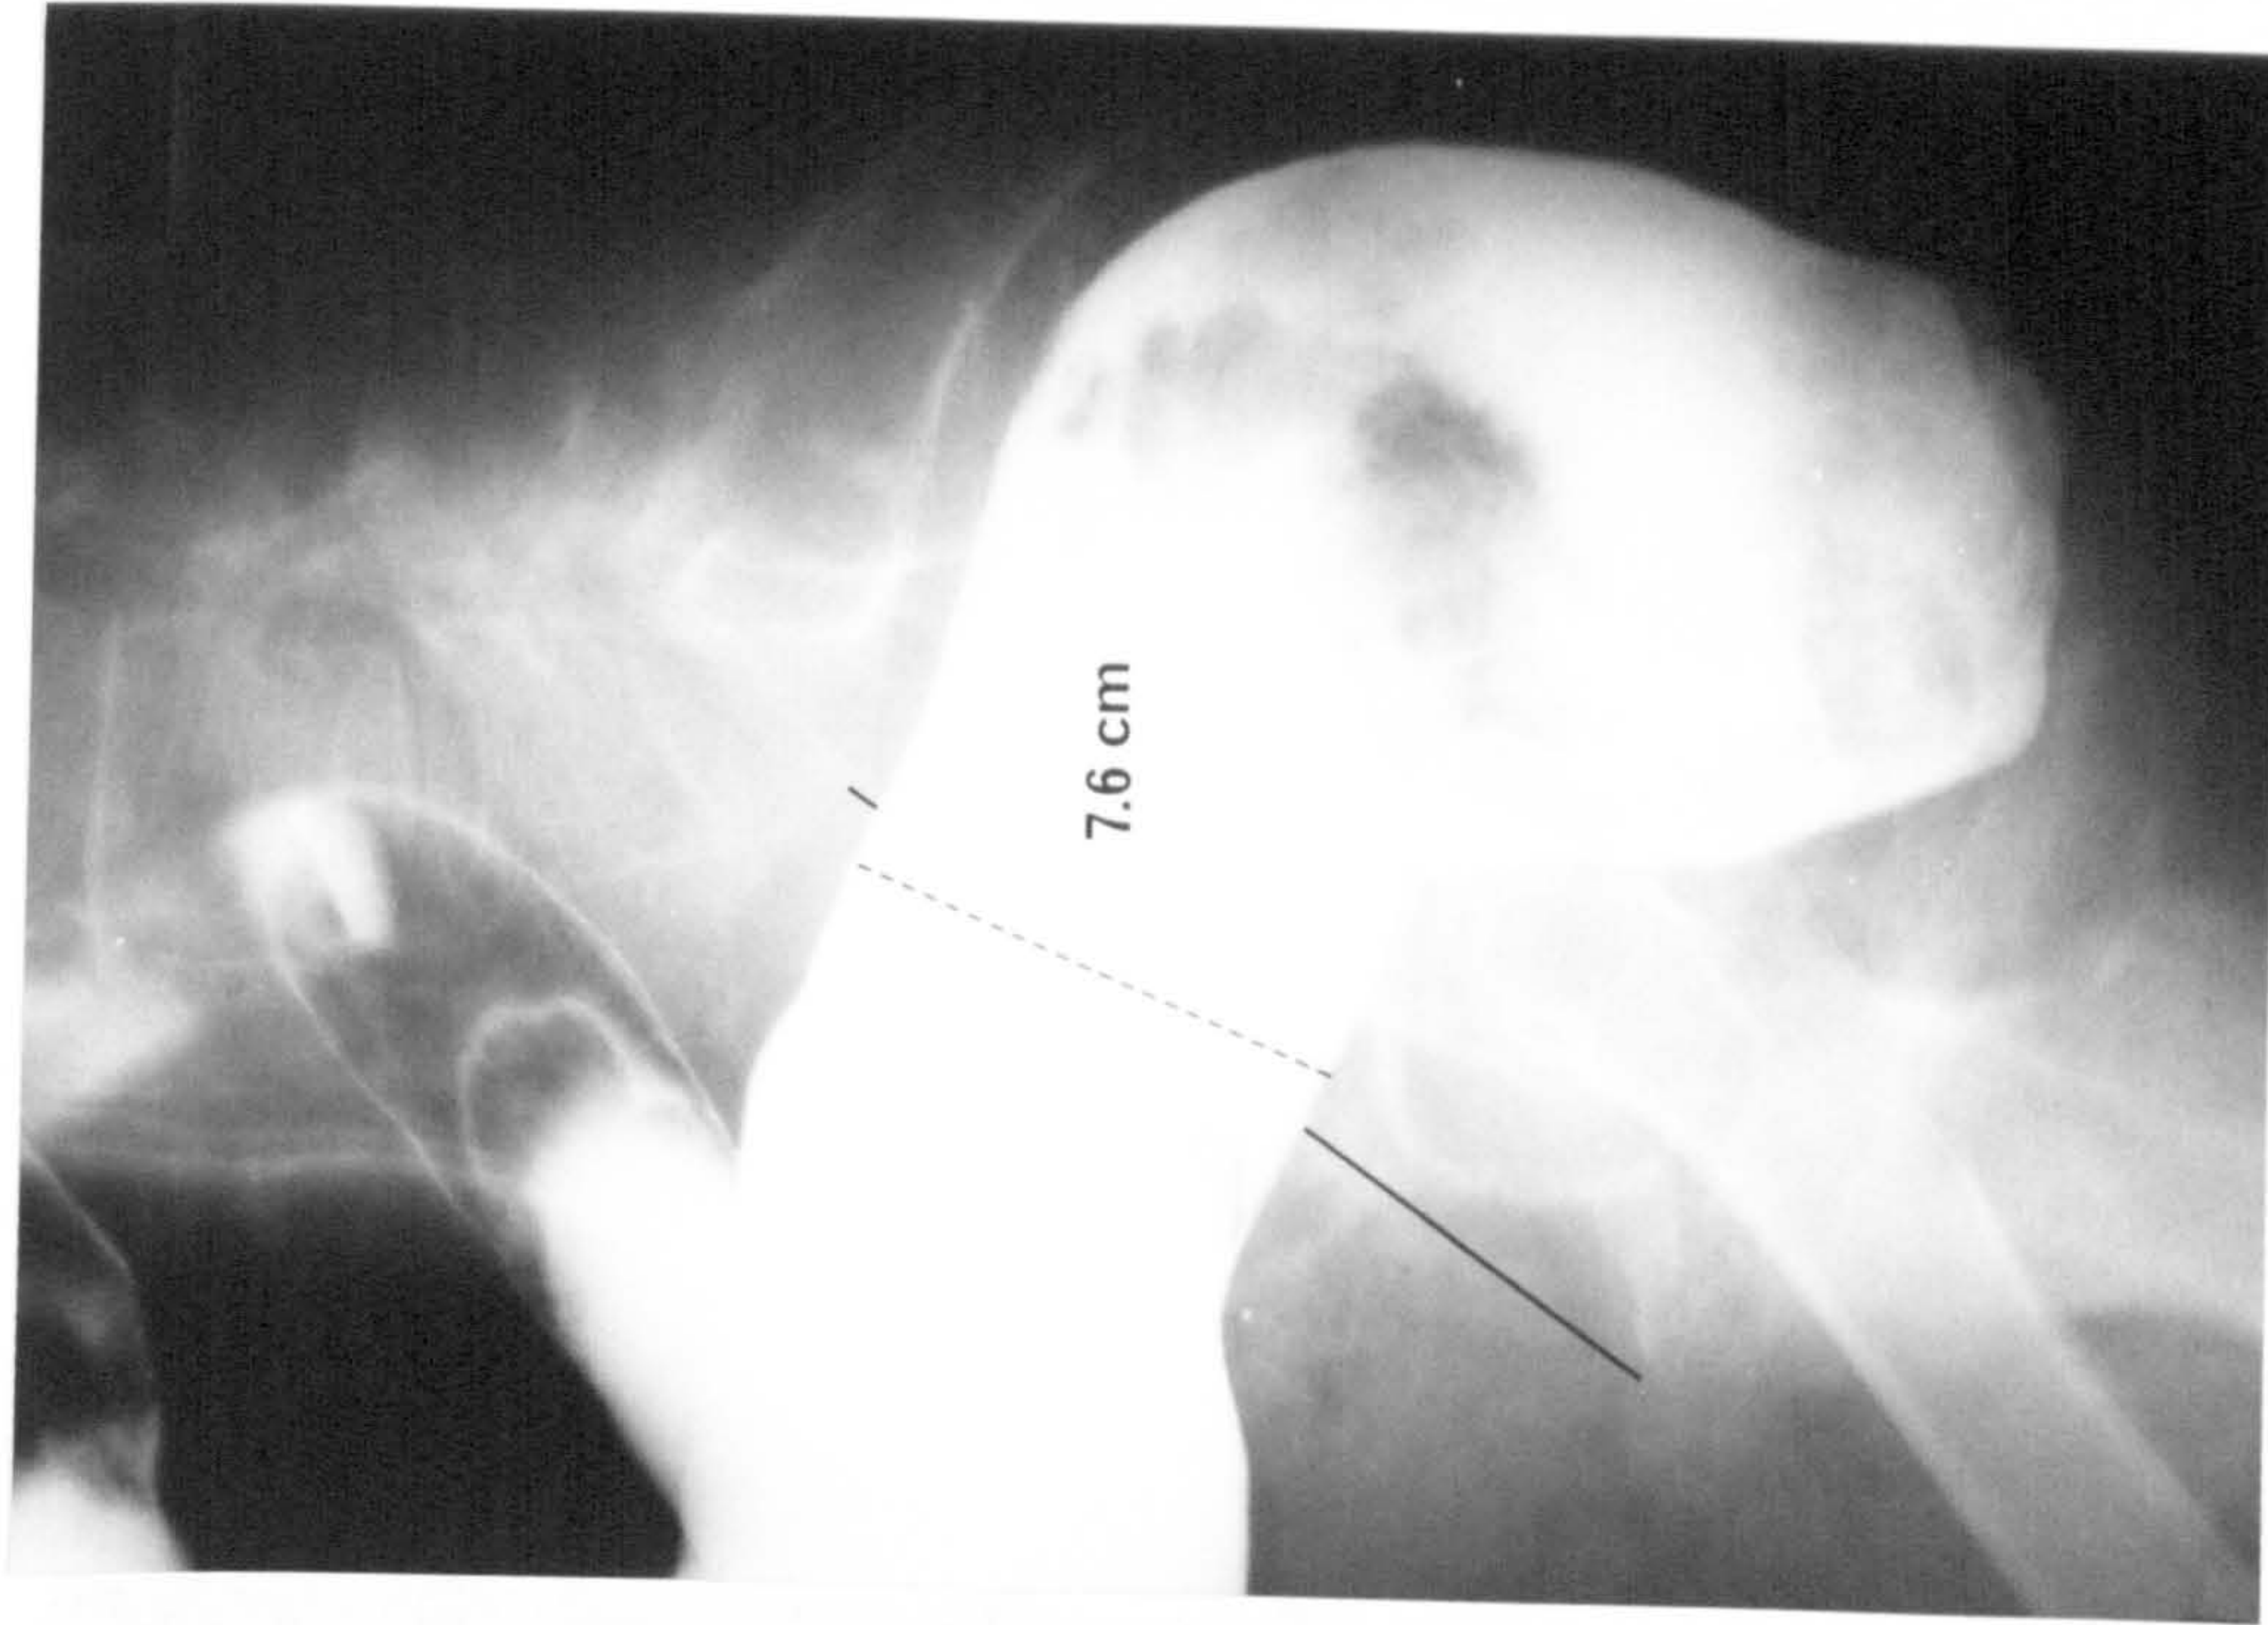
LATERAL PELVIC RADIOGRAPH TAKEN FROM A PATIENT WITH IDIOPATHIC MEGACOLON
